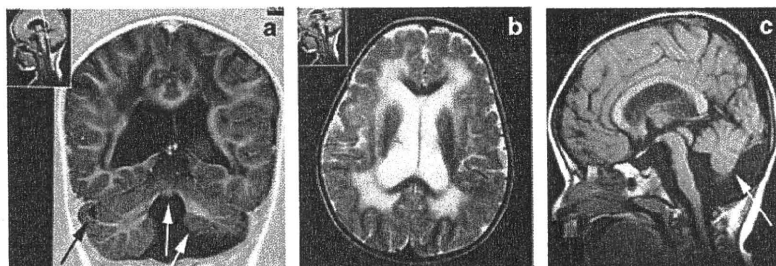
Brain MRI images obtained from Patient 1 performed at an age of 3.5 years. (a) Coronal T1-weighted image showing cerebellar and vermis hypoplasia (white arrows), cerebellar cysts (black arrow), generalised white matter atrophy and increased CSF spaces. (b) Transverse T2-weighted image showing abnormal high white matter signal and dilated lateral ventricles. (c) Sagittal T1-weighted image showing cerebellar (white arrow) and pontine hypoplasia.
